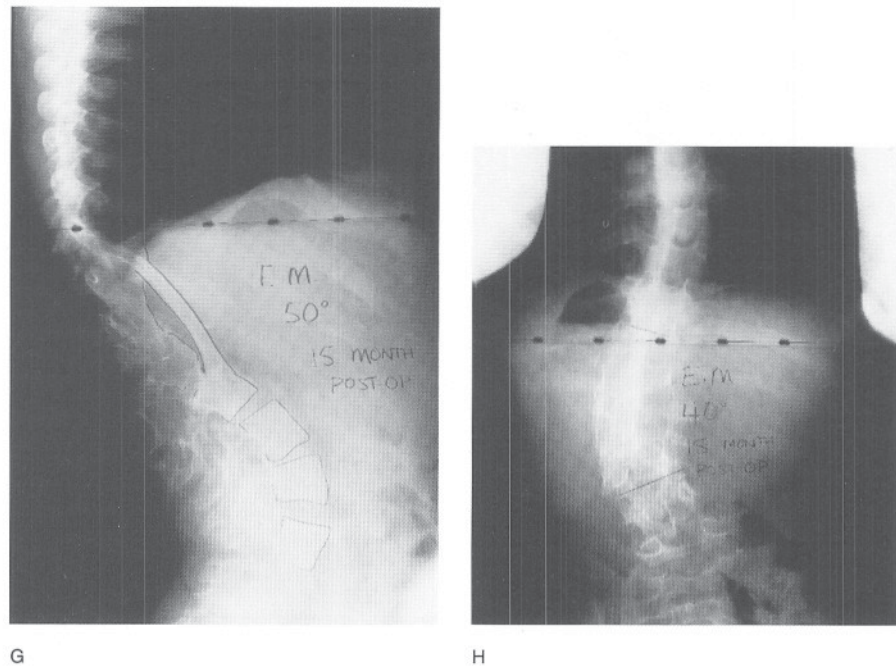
Continued.* G and H, Fifteen months postoperatively, the kyphosis was stable at 50 degrees and the scoliosis was at 40 degrees. Five years later the radiographic appearance was unchanged and the patient remained neurologically normal.
